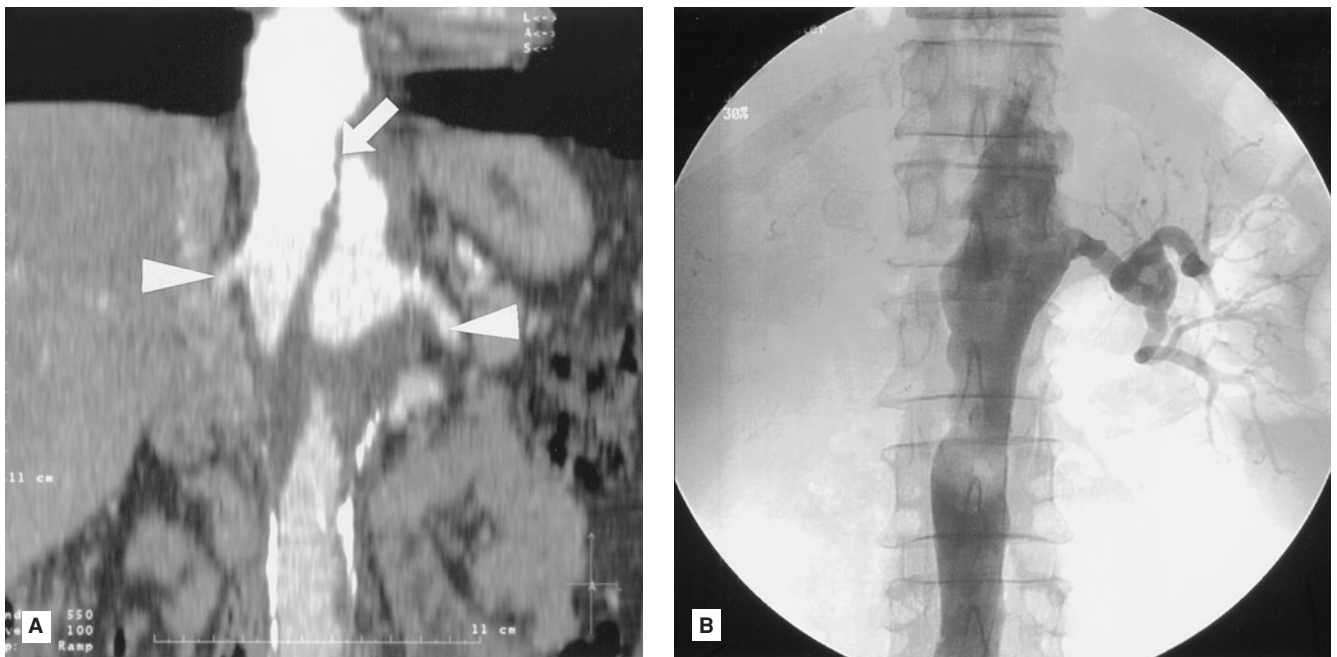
Coronal view of contrast-enhanced MRI (A) demonstrating chronic type B dissection with renal arteries (arrowheads) separated by the dissection flap (arrow). Aortogram (B) of the same patient revealing that each renal artery is perfused exclusively by either the true or false lumen. Such tests are often complementary and may influence surgical strategy.
